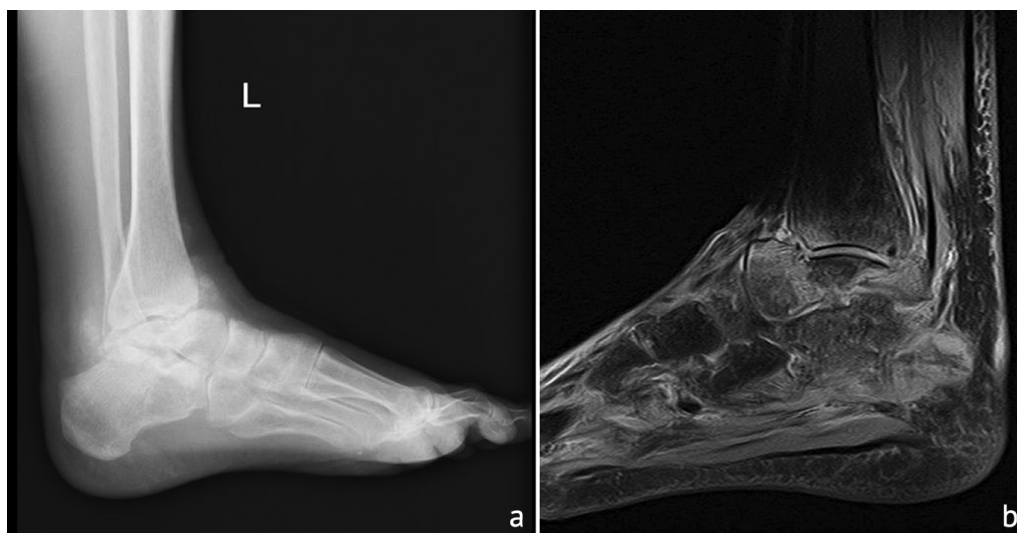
Radiograph and MRI of the ankle joint and foot upon admission: *a* the radiograph shows unclear edges of osteodestruction and cloud-like foci of osteoproliferation; *b* MRI in fat-suppression mode shows pronounced bone marrow edema of the talus, navicular, tibial head and calcaneus, destruction of the talus, calcaneus and, to a lesser extent, navicular bone
